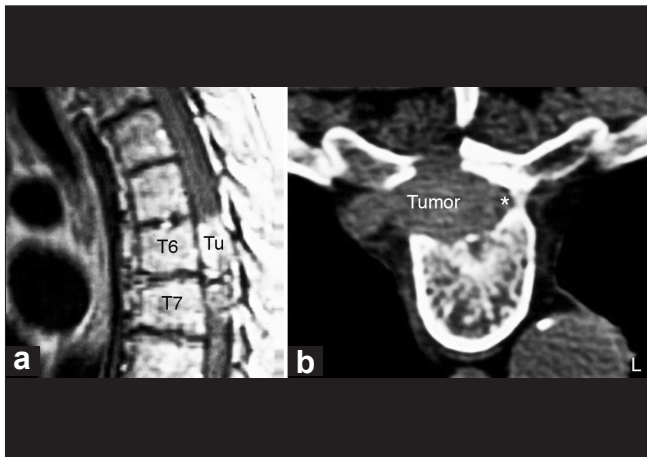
(a) MRI scan demonstrating intraspinal PMS. Tu = tumor. (b) The spinal cord is displaced to the right (asterisk), along with erosion and enlargement of the right T6–T7 intervertebral foramen and extension into the posterior mediastinum
